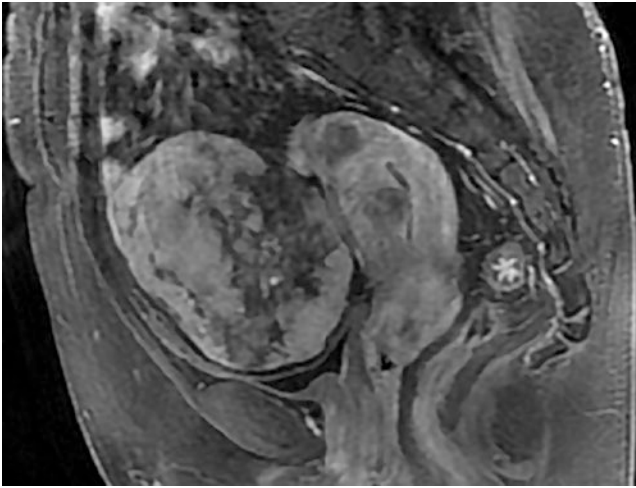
Sagittal T1-weighted contrast-enhanced image showed the mass was heterogeneous. It had marked enhancement equal to myometrium after contrast enhancement
